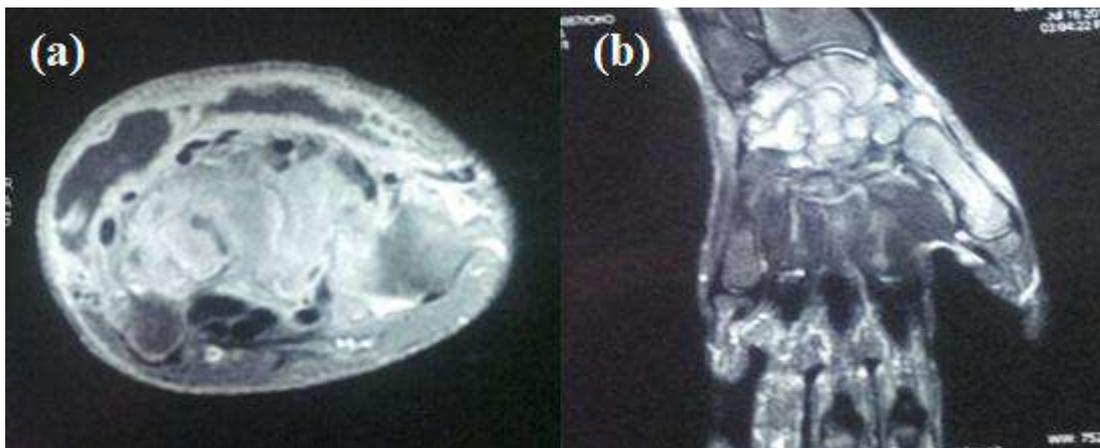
MRI of the wrist (a: axial cross-section, b: frontal cross-section) Osteoarthritis of the wrist was showed with Spongy edema of the carpal bones, synovial thickening, liquid articular effusion and peri-articular abscess
